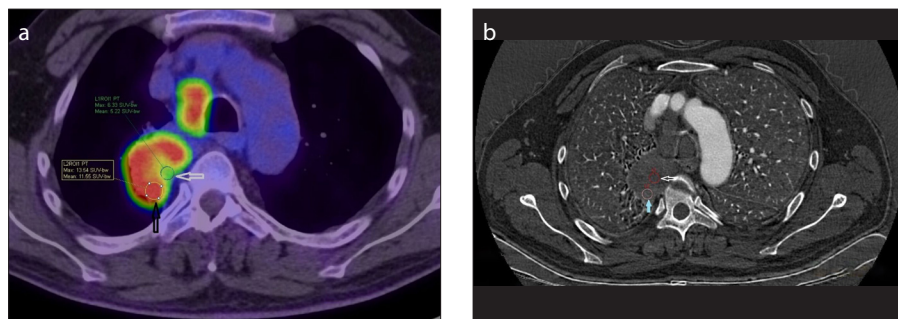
a, b. Transaxial ^{18}F -FDG PET/CT fusion image (a) and transaxial iodine mapping image (b) show a 62-year-old man with right lung adenocarcinoma; simultaneous measurements were taken from the posterior viable portion of the tumor. The axial cross-section with the most intense FDG uptake was determined and a ROI was drawn on the fusion image of ^{18}F -FDG PET/CT (a, black arrow) and a ROI with the same size was drawn around the same cross-section on the DESCT (b, blue arrow; ICmean, 11.02 mg/mL) and measurements were recorded. The necrotic region with a low FDG-uptake was observed in the medial side of the central portion of the tumor; this region was not included in the evaluation (a, white arrow, SUVmax, 5.2; b, white arrow, ICmean, 3.3 mg/mL).
